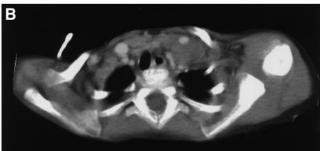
CT image of large abdominal neuroblastoma (A) in 15-mo-old child who also had left supraclavicular tumor (B), but no involvement of cortical bone or bone marrow (stage "IV-N"). Abdominal mass was resected, biologic markers were favorable, and no cytotoxic therapy was administered. Distant disease spontaneously regressed, and child is well 4+ y later.
